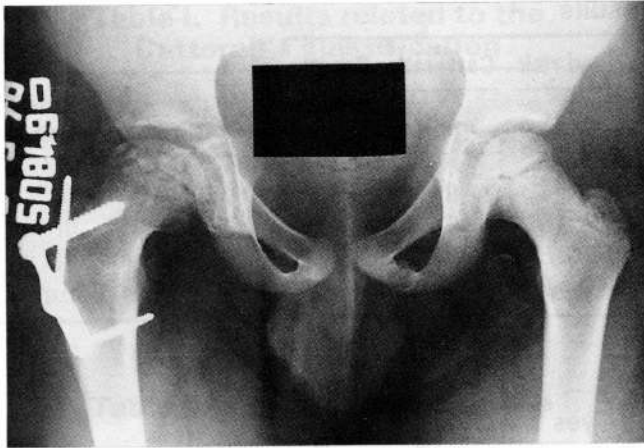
X-ray of the hip in reparative stage.
